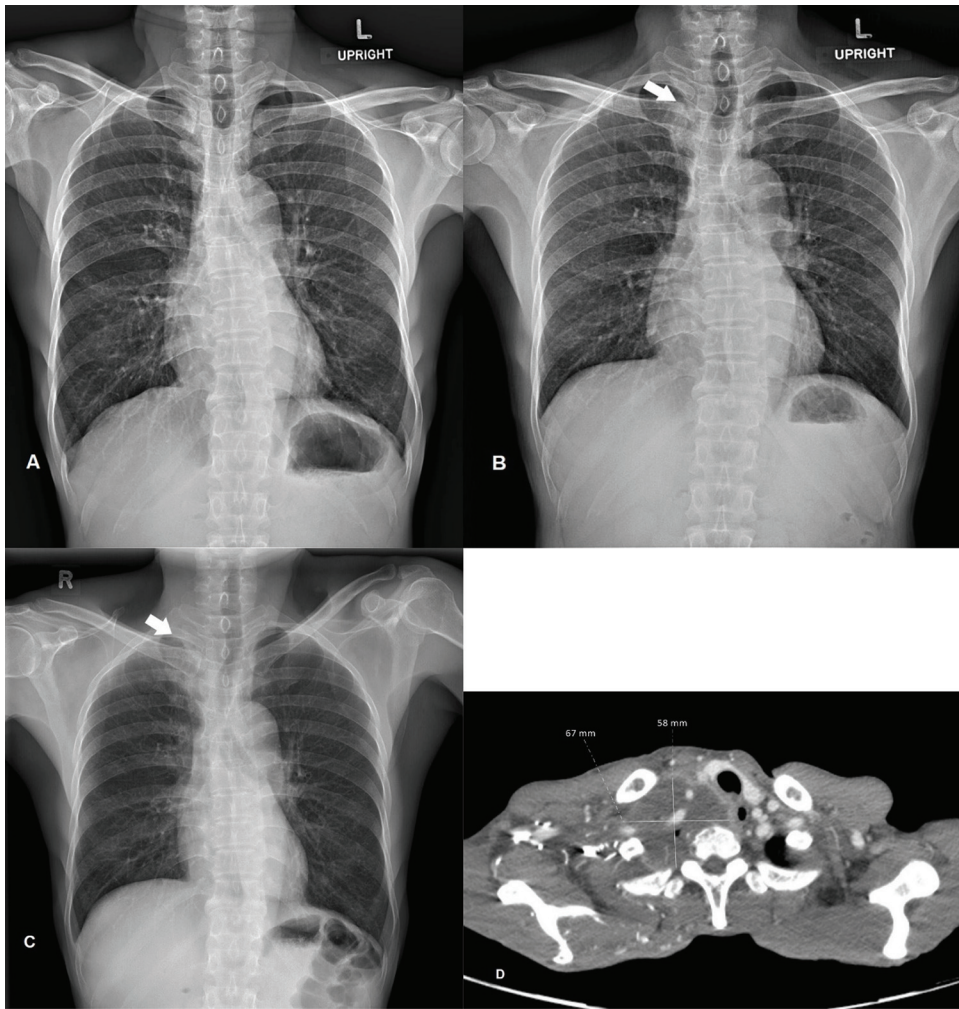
A 53-year-old man with hoarseness for 90 days. (A) His first chest radiograph was normal. (B) His followed up chest radiograph 39 days after the first visit revealed only a slightly prominent soft tissue at the right paratracheal stripe and mild tracheal shifted to the left side (white arrow). (C) His followed up chest radiograph at 120 days showed an increased size of a soft tissue lesion at the right paratracheal stripe and increased tracheal shifted to the left side (white arrow). (D) CT scan showed a Pancoast tumor at right apical lung, encasing the right common carotid artery and right subclavian artery and invading the superior venacava. The tumor size is about 5.8×6.7 cm.
